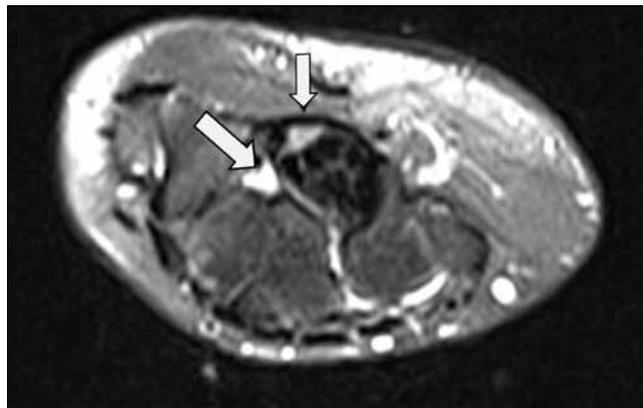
White arrows in T2-weighted MRI appearance of ganglion cyst in wrist.
